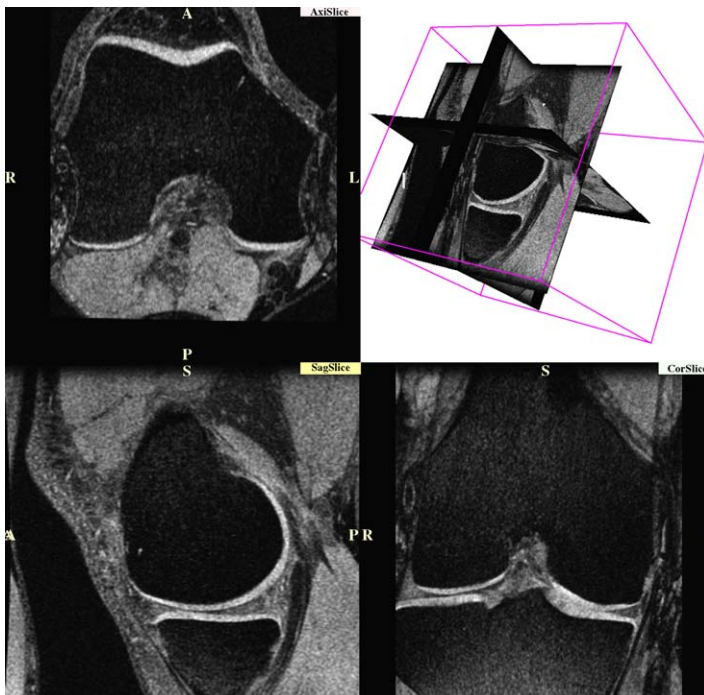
Simultaneous multiplanar display of three-dimensional FSE images, 3-T MR image. The three-dimensional FSE sequence is acquired with near isotropic resolution ($0.47 \times 0.6 \times 0.5$ mm). Images can be displayed in any desired plane without apparent loss in image quality. Partial volume artifacts are greatly reduced using this approach.
